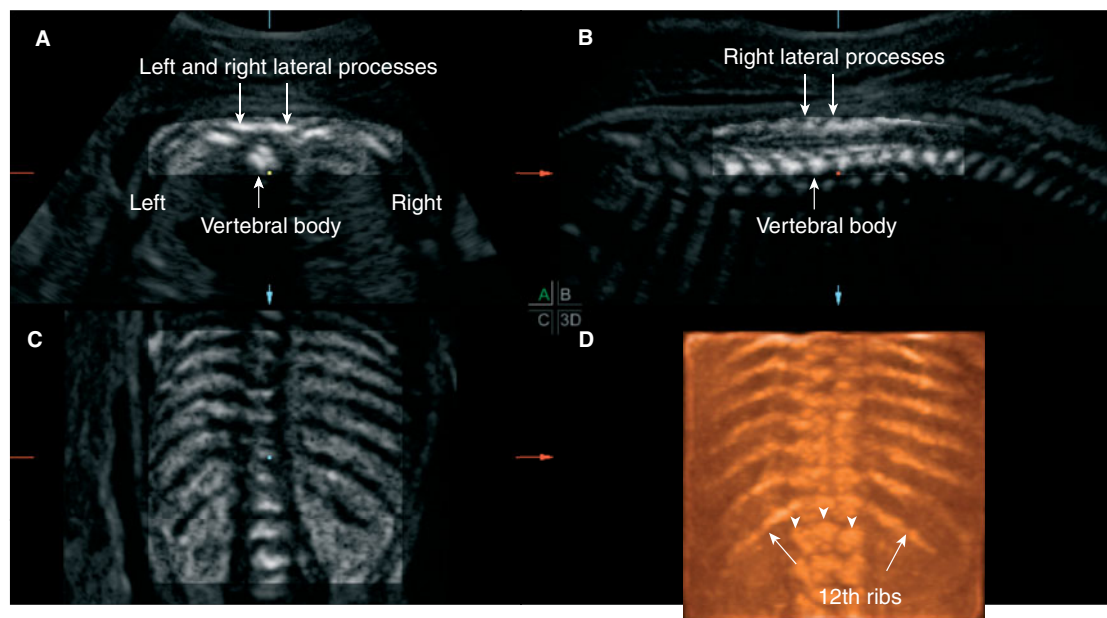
Multiplanar mode and maximum or x-ray display of the fetal spine and ribs at 20 weeks' gestation. This mode allows simultaneous visualization of the three orthogonal planes of the spine and evaluation of the three ossification centers, the lateral processes, and the bodies of the vertebrae. Axial plane in box A, sagittal plane in box B, and coronal plane in box C. Note that the ribs are not demonstrated in box C, but their shadow is visible, since the marker dot is placed on the body of the vertebrae anterior to the level of the ribs. The maximum mode was applied to obtain the rendered image as demonstrated in box D, which allows the identification of the 12th ribs and visualization of the three ossification centers simultaneously (arrowheads).
